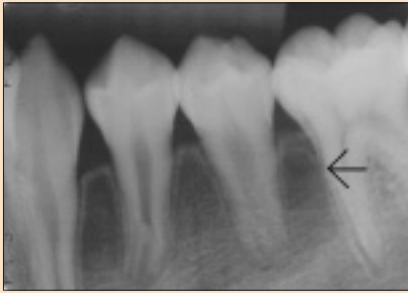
Periapical radiograph of tooth 35 shows a circumscribed radiolucency between tooth 35 and tooth 36 (arrow).
